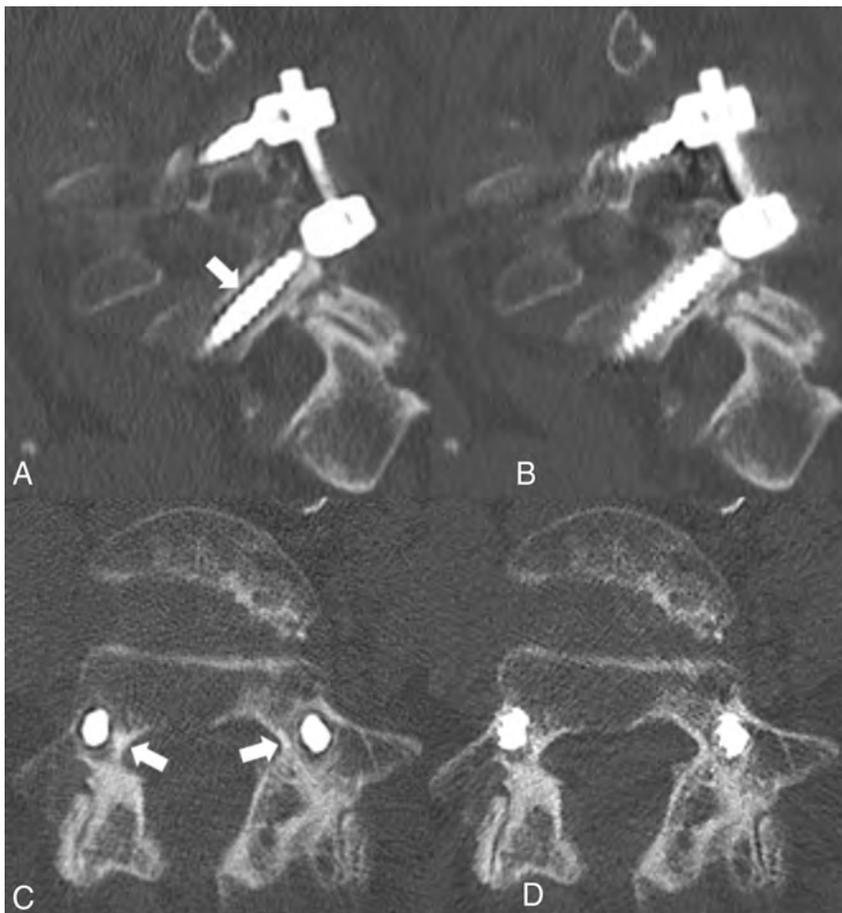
A*, Sagittal CT image of posterior lumbar spinal fusion with the MAR technique applied shows lucency surrounding the L5 pedicle screw as indicated by the *white arrow*. *B*, Image *A* without the MAR protocol applied. *C*, Axial CT image shows bilateral pedicle screws with the MAR technique applied, demonstrating lucency surrounding the bilateral pedicle screws (*white arrows*). If the MAR images were viewed alone, these lucencies could be mistaken for hardware loosening. *D*, Image *C* without the MAR protocol applied.
